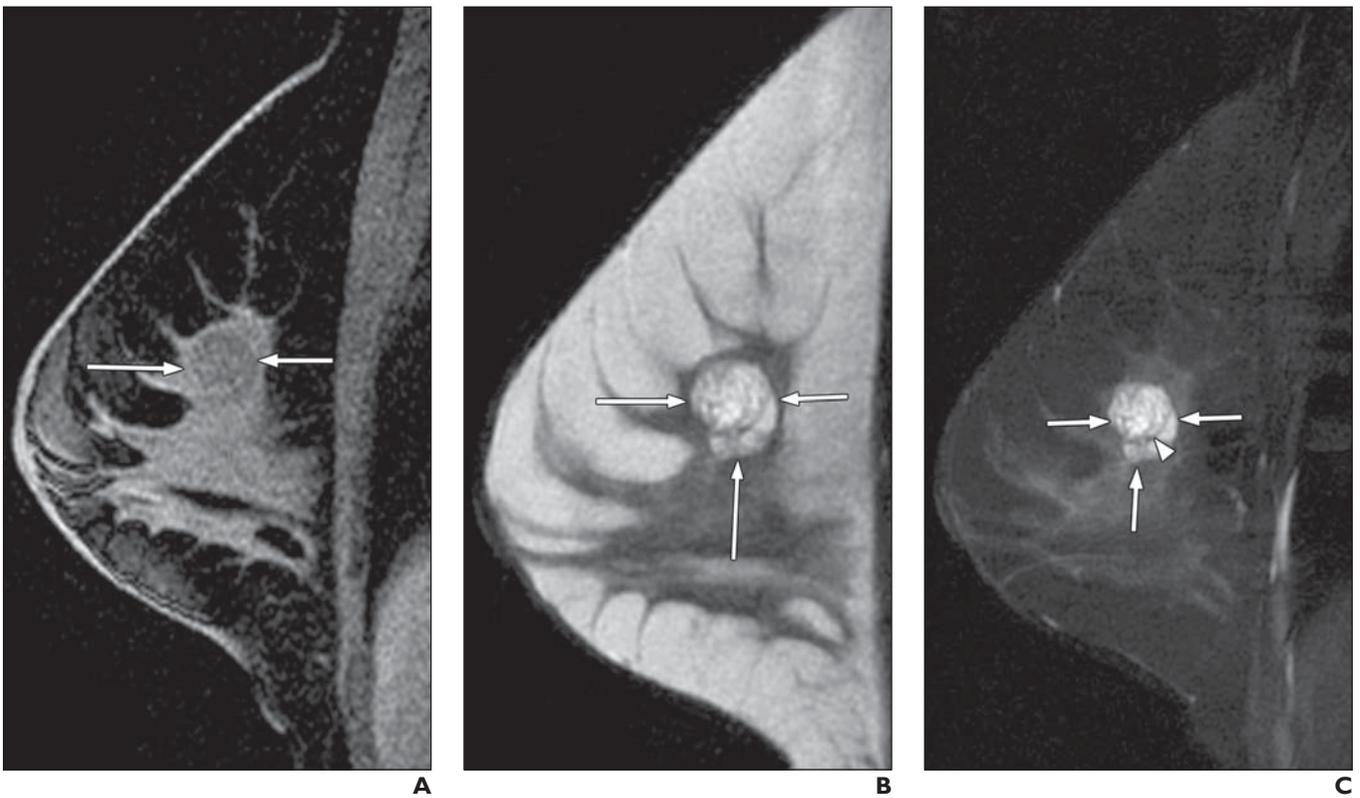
Complicated cysts in 48-year-old woman with history of premenopausal breast cancer who presented for screening MRI. A–C, Hyperintense circumscribed mass (*arrow*) is seen on T1-weighted (A) and T2-weighted (B) images because of proteinaceous or sanguineous contents of cystic fluid. Note thin rim of enhancement on contrast-enhanced image (C).
